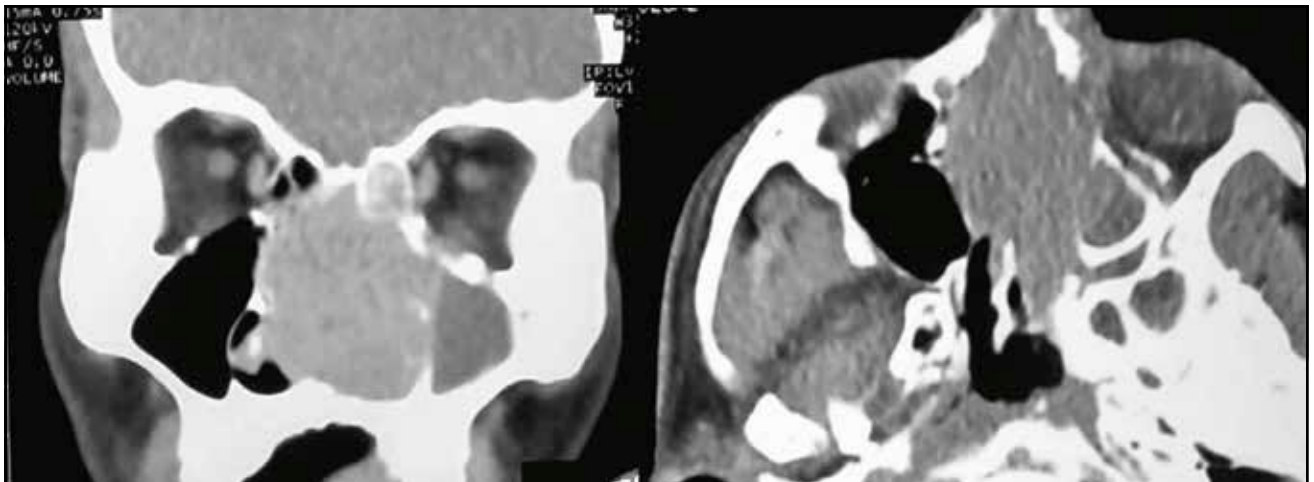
Contrast-enhanced cranio-facial CT scan, axial and coronal sections, showing a speculated reaction of the cortical bone of the left nasal bone.
